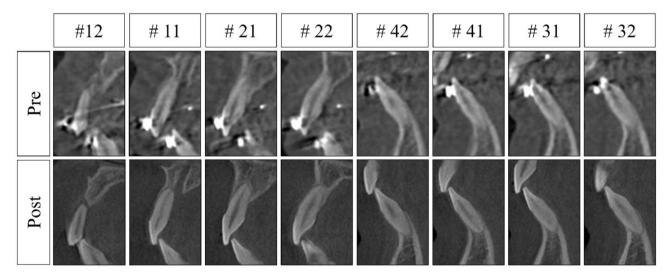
CBCT slices showing the root status of the upper and lower central and lateral incisors
